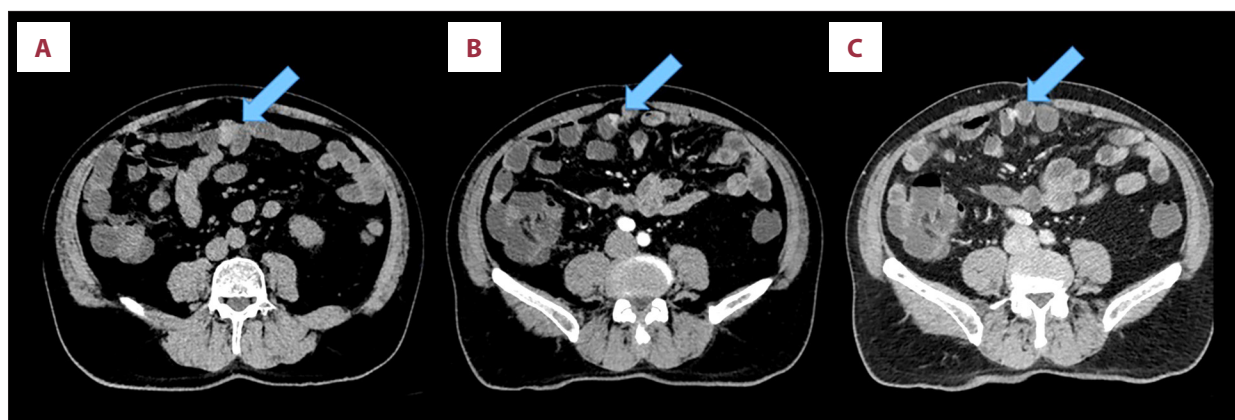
(A) Unenhanced sagittal computed tomography image demonstrating a distal ileal nodular lesion measuring 11 × 8 mm with attenuation of approximately 75 Hounsfield units; no mural thickening, obstruction, lymphadenopathy, or desmoplastic reaction is evident. (B) Arterial-phase and (C) portal venous-phase sagittal computed tomography images demonstrating pronounced arterial hyperenhancement without venous washout, consistent with a hypervascular small-bowel mass and potential source of bleeding.
